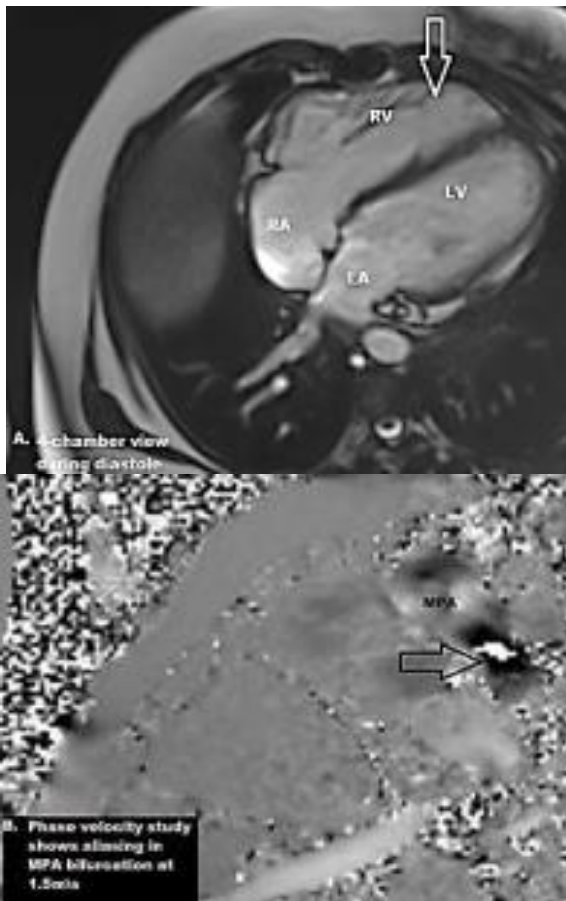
MRI study, (A) axial 4-chamber view shows RV dilatation (arrow), (B) phase velocity sequence for MPA IP shows aliasing at 1.5m/s (arrow) denoting MPA stenosis.
